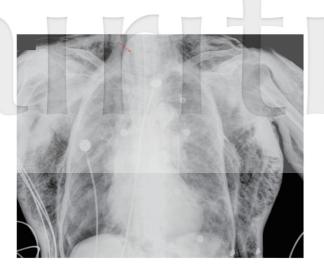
Supine anteroposterior chest radiography shows pneumomediastinum (arrow) and diffuse subcutaneous emphysema in chest wall and neck.
